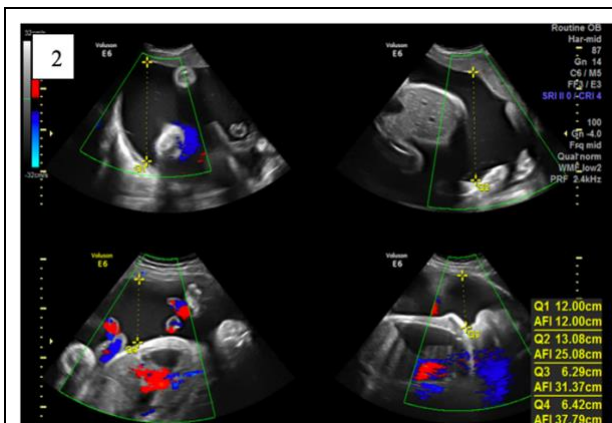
Ultrasound at 31 weeks' gestation with increasing polyhydramnios of 37.8cm.
